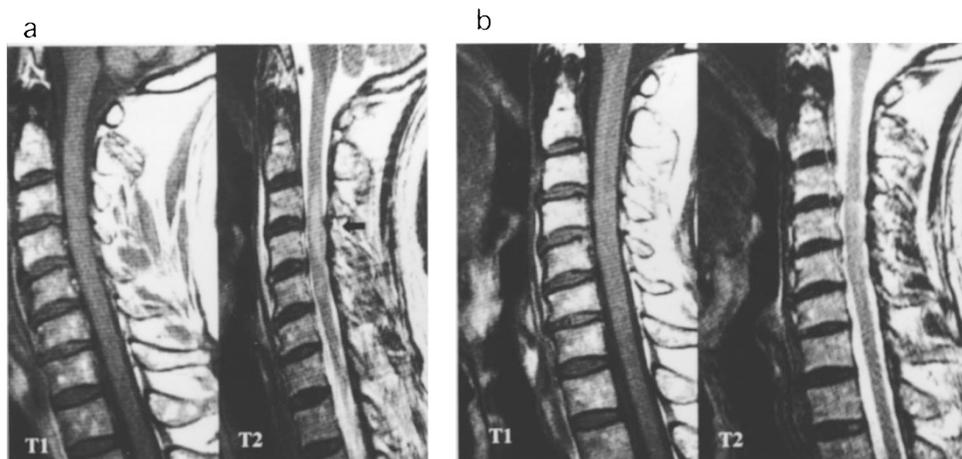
A 64-year-old man. Paralysis was grade C in the acute stage and recovered to grade D by 12 months after injury. (a) MRI at 48 h after injury. T2-weighted images showed an indistinct high signal intensity area (black arrow). (b) MRI at 4 weeks after injury. The high signal intensity area had almost disappeared. There were no signal changes on T1-weighted images from the acute to the chronic stage
